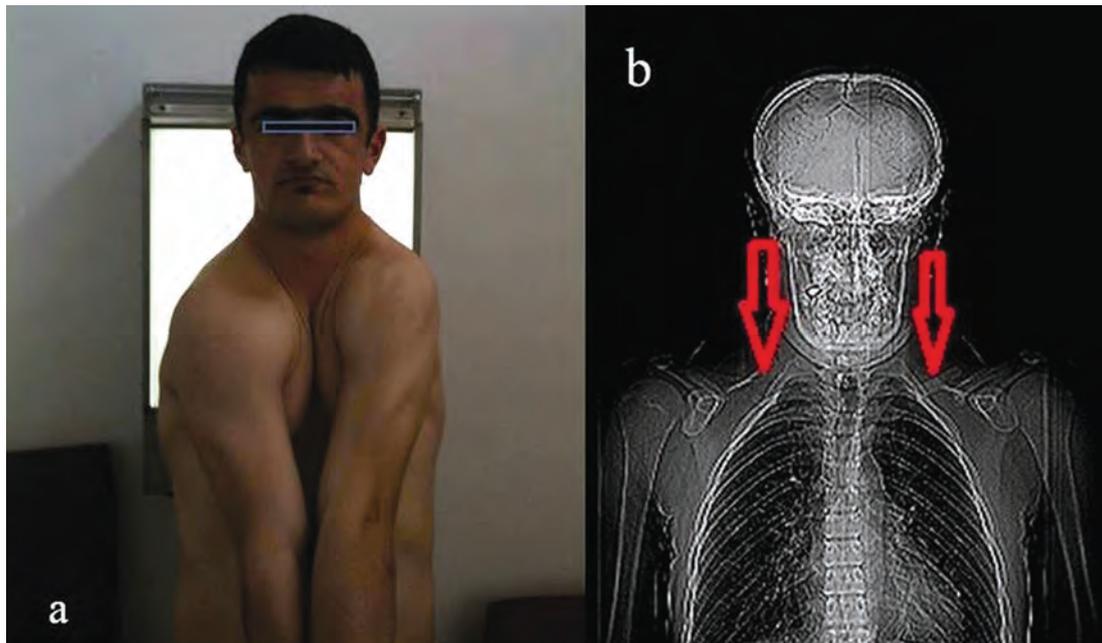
Extensive mobility of shoulders (a) and partial absence of clavicles (red arrows) and bell shaped rib-cage on the chest radiography (b).
